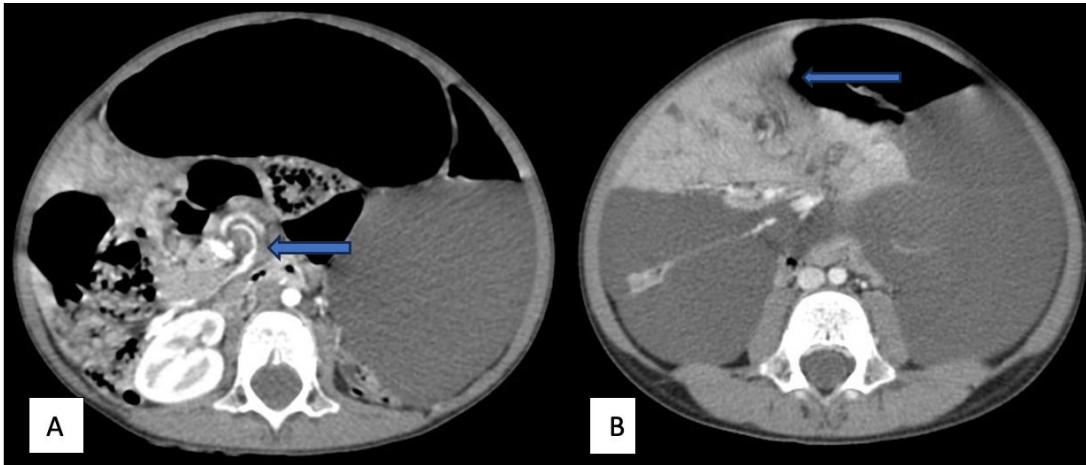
CT scan showing: (A) whirlpool sign and (B) cystic lesion formation.
